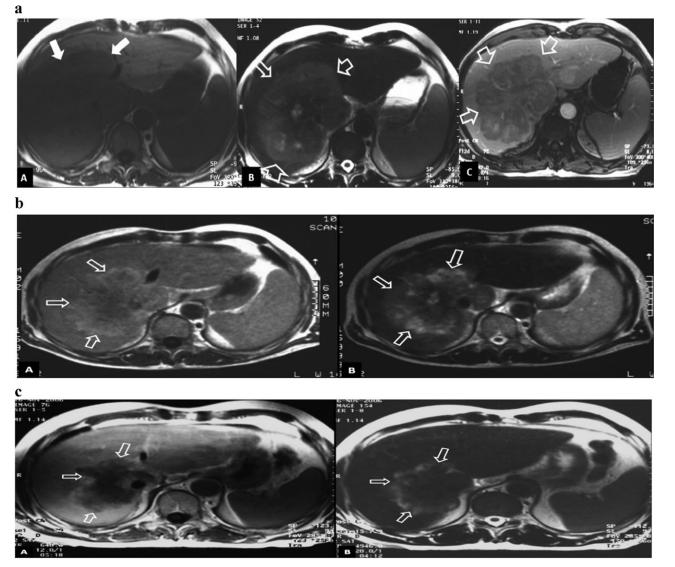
Hepatocellular carcinoma patient. (a) Pre-vaccination imaging studies. The T1-w (A), T2-w (B) and contrast enhanced T1-w (C) axial magnetic resonance (MR) images show the initial size of the hepatic neoplasm (arrows). (b) The 6-month imaging follow-up study shows reduced size of the lesion on both the T1-w (A) and T2-w (B) axial MR images (arrows). (c) The 10-month imaging follow-up study shows a further reduction of the size of the lesion on both the T1-w (A) and T2-w (B) axial MR images (arrows).
